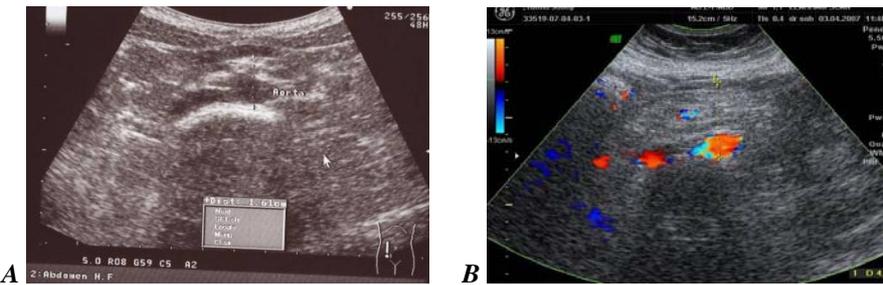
Measurement of visceral fat from abdominal muscles to posterior aortic wall. A. In non obese control. B. Complementary color Doppler is used in that case (obese control) for better visualization of the aorta.
